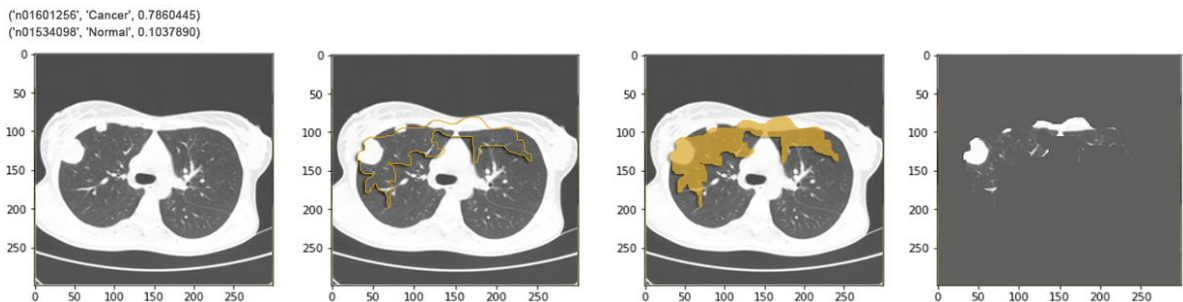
LIME result of CT image with a model of ResNet50
